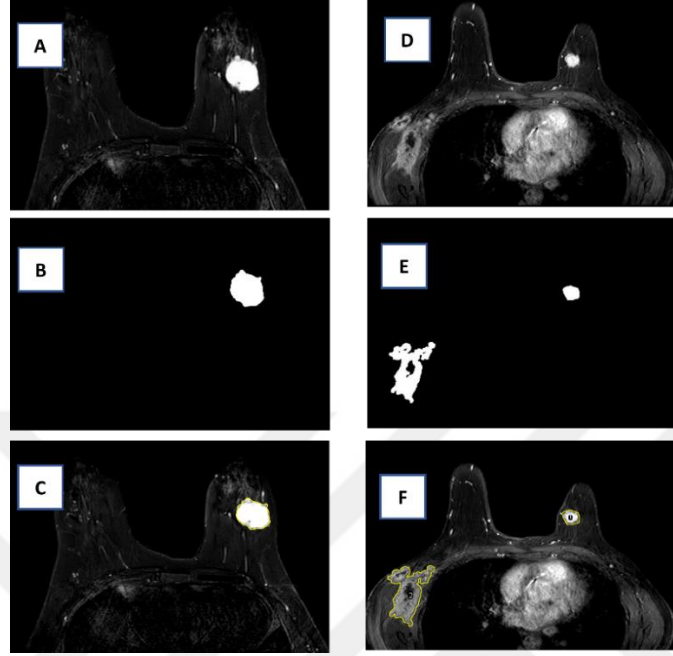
T2 weighted (T2W) image (left) and 7dynamic-Enhanced (7dyn) T1 High Resolution Isotropic Volume Excitation MR image (right); (A, D) original MR images; (B, E) segmented mask images, (C, F) Selected ROI
